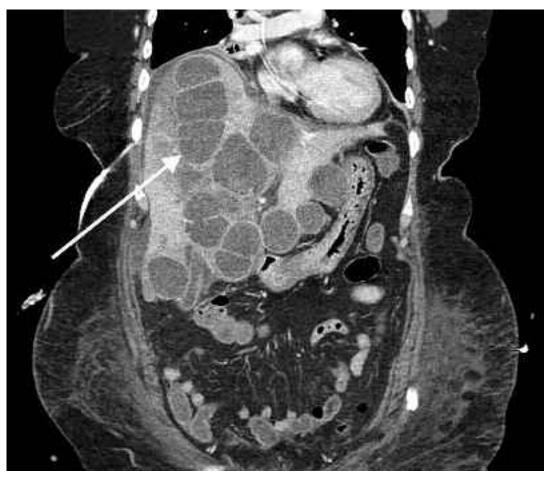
Abdominal computed tomography (coronal) image demonstrating multiple hepatic collections consistent with abscesses.
